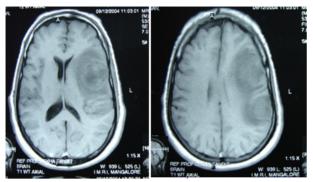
MRI T1W images showing lesions are isointense to brain parenchyma
